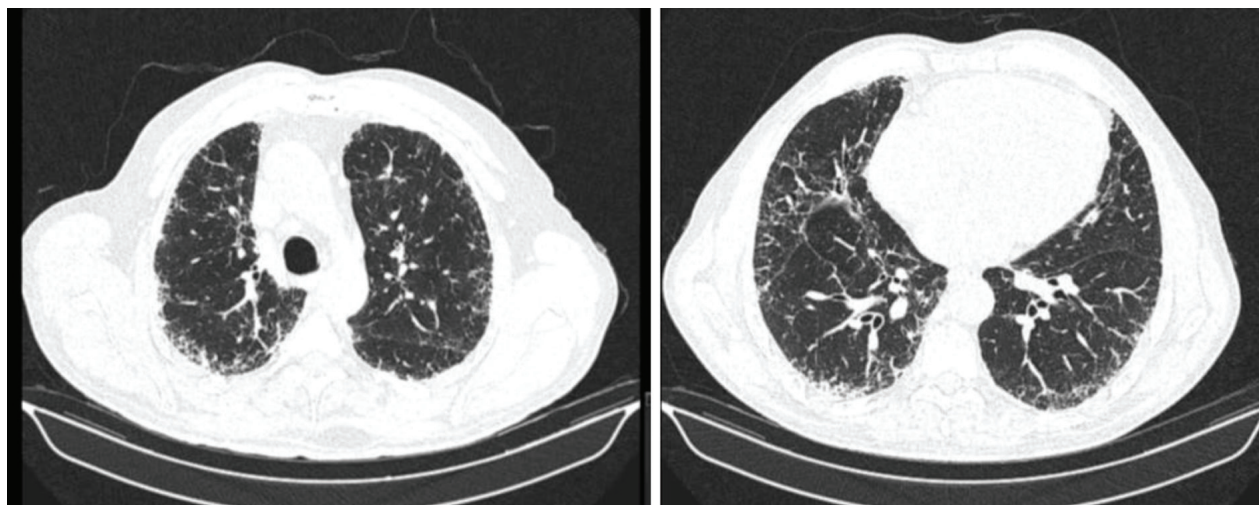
Chest high resolution computed tomography, showing subpleural reticulation, scarce traction bronchiectasis, without predominantly basal distribution. Defined as a probable usual interstitial pneumonia (UIP) pattern.
